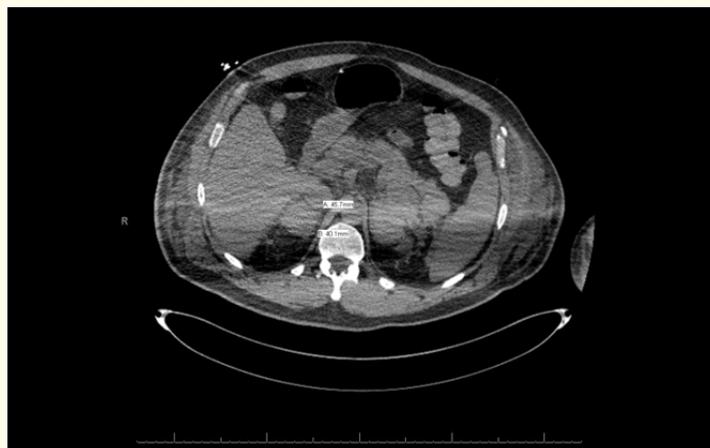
CT abdomen and pelvis demonstrating bilateral large adrenal hemorrhage.
